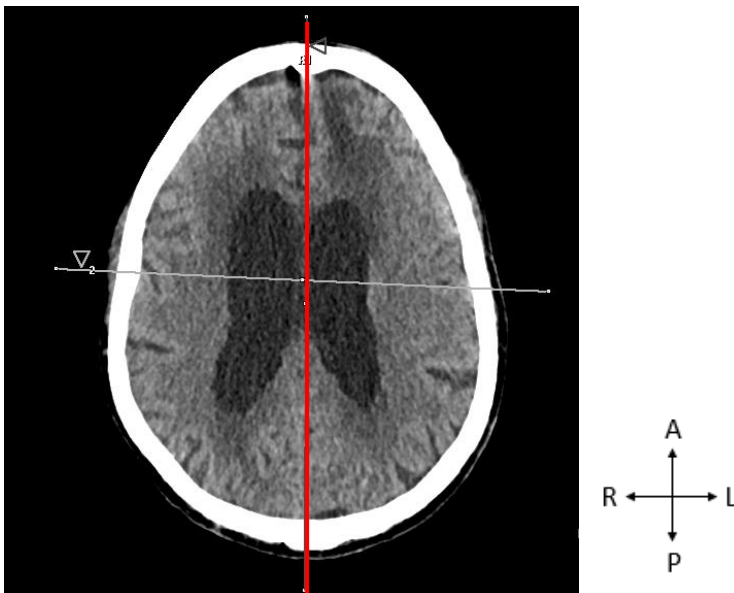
A CT scan showing the brain in the axial view indicating the midsagittal reference line (red). Image taken from the GSH PACS (20 October 2023). A - Anterior, R - Right, P - Posterior, L - Left.
